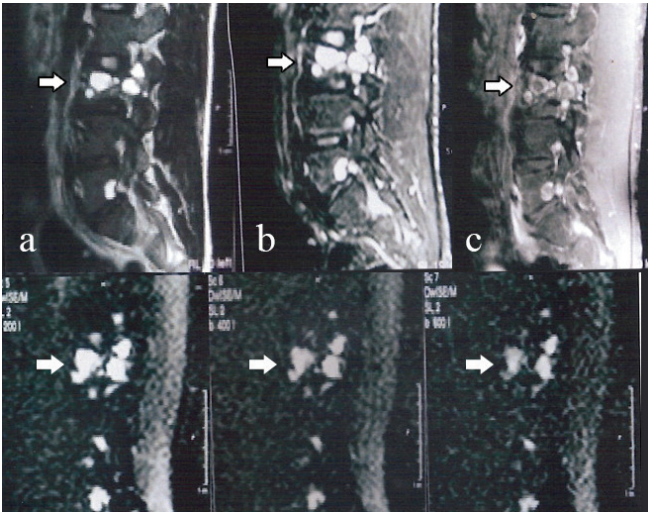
74-year-old man with prostate adenocarcinoma had metastatic vertebral fractures at L3 (arrow) and L5 vertebra which show low signal intensity on sagittal T1-weighted sequence (a), high signal intensity on sagittal T2-weighted SPIR sequence (b), contrast enhancement on sagittal post-contrast T1-weighted SPIR sequence (c) and high signal intensity on sagittal DWI at b value of 200 (d), 400 (e) and 600 s/mm² (f).
